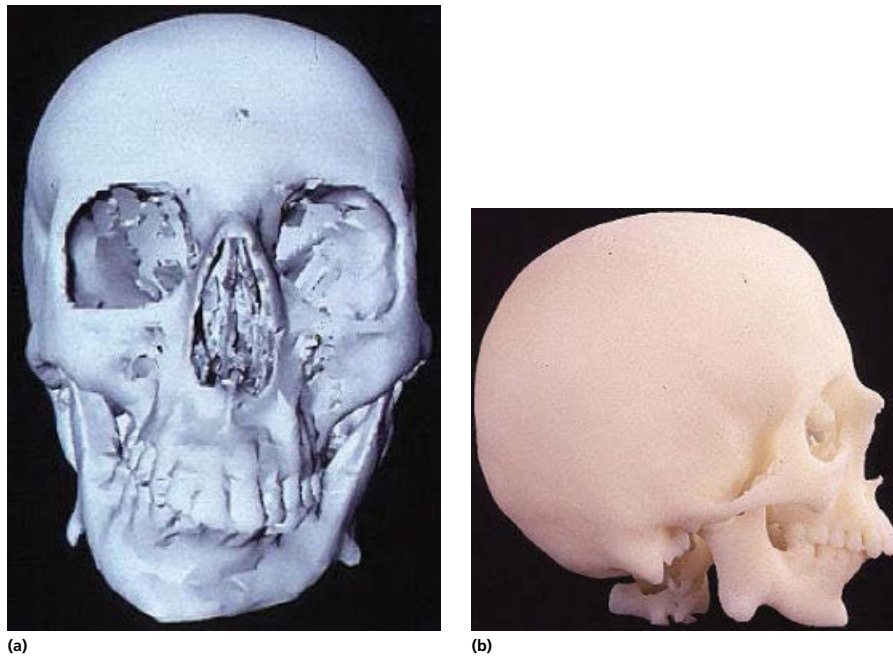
(a) A 3D CT image of a patient injured in infancy, there is left temporomandibular joint ankylosis and a typical growth deformity. (b) A nylon model showing the pathology can be useful when planning reconstructive surgery.
